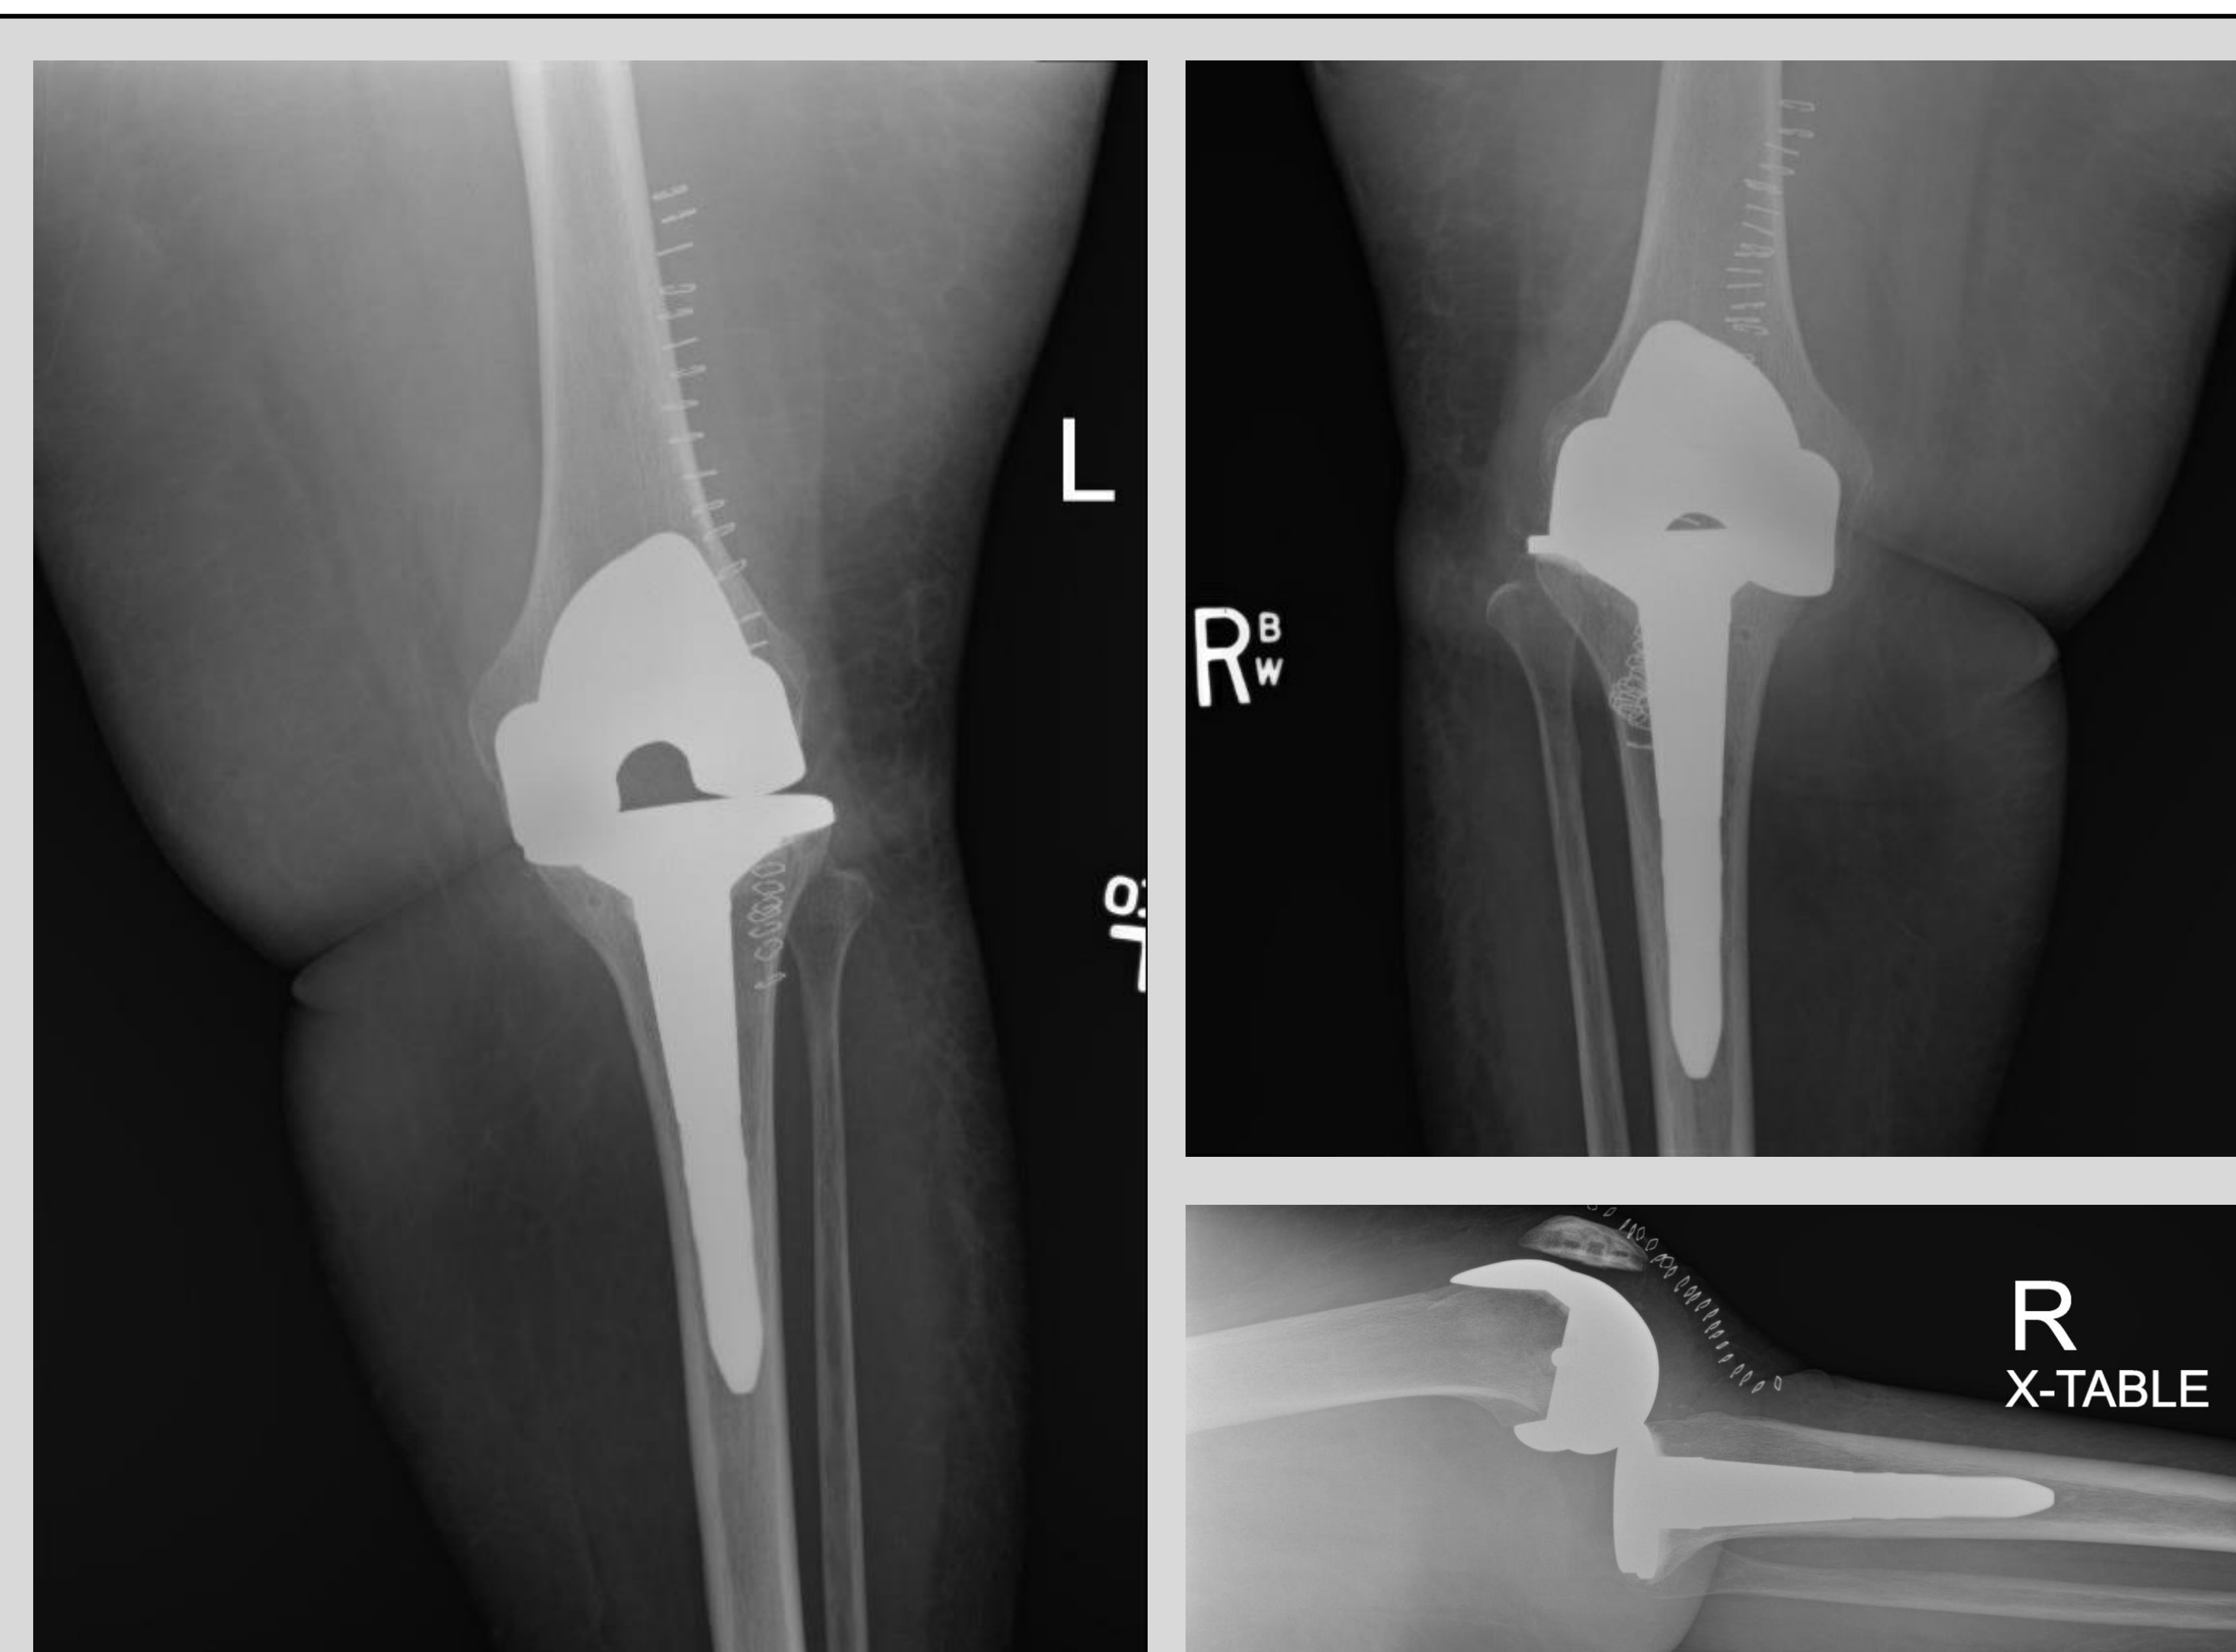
Anteroposterior (AP) left knee radiograph depicting posterior subluxation of the tibia under the femur.
